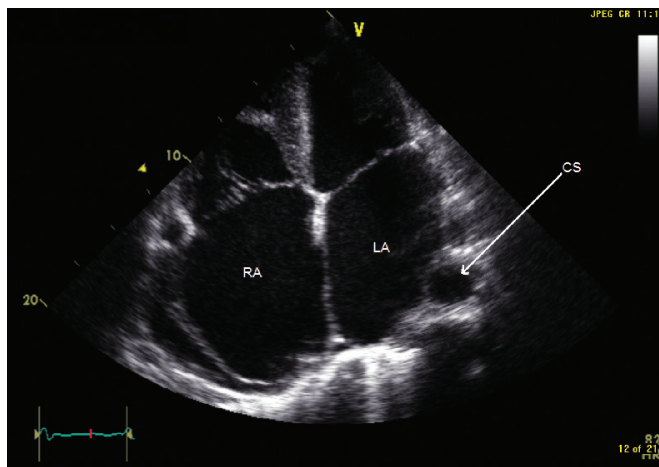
Transthoracic echocardiographic apical 4-chamber view showing dilatation of all cardiac chambers with a markedly dilated coronary sinus (CS). RA indicates right atrium; LA, left atrium.
